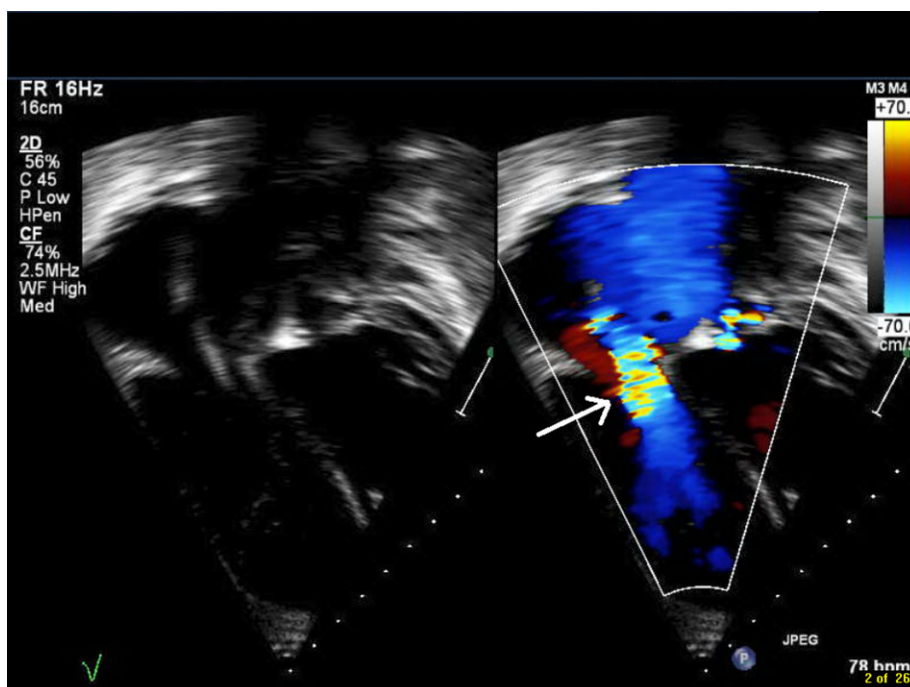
Right: Transthoracic echocardiogram/Doppler study in the four-chamber view, demonstrating a moderate-severe degree of tricuspid valve insufficiency (arrow) associated with a 6-Fr diameter lead. Left: With the Doppler signal off, the 6-Fr diameter pacemaker lead is readily visible traversing through the tricuspid valve.
